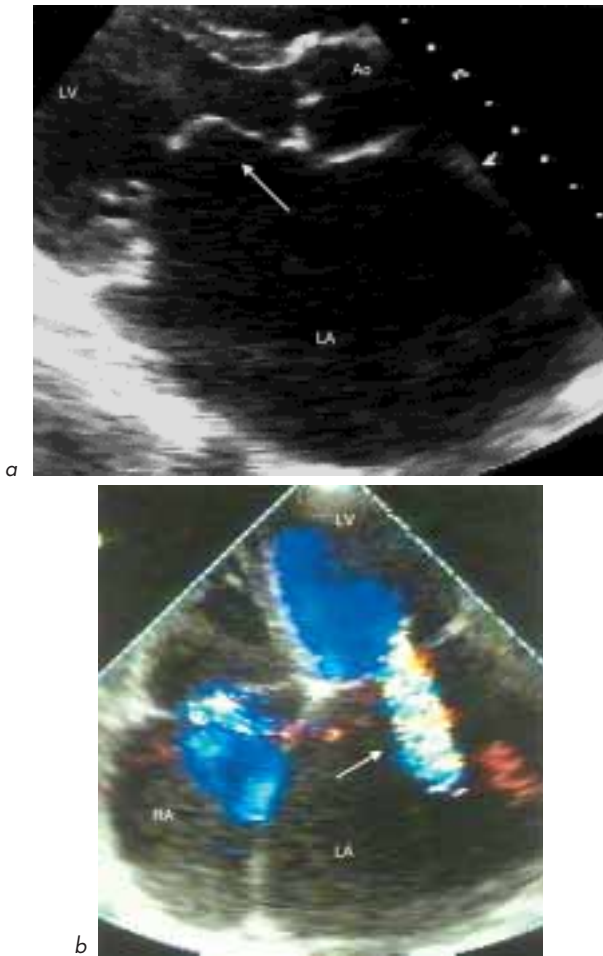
Rheumatic mitral regurgitation and stenosis. The left atrium is very enlarged. (a) The anterior leaflet shows 'elbowing' (arrow) on parasternal long-axis view. (b) A jet of mitral regurgitation is seen (arrow) on colour flow mapping in the apical 4-chamber view.
